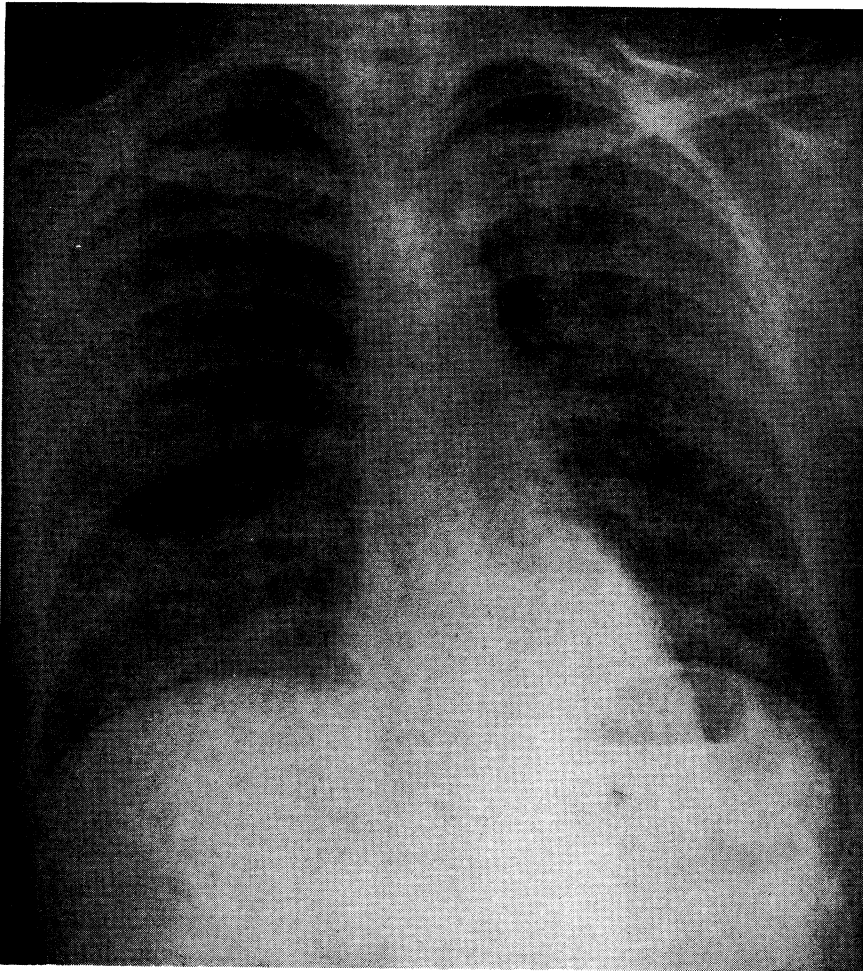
Roentgenogram of the chest of case 2, showing bilateral diffuse, patchy and confluent infiltrations throughout the middle two-thirds of the lung fields.
